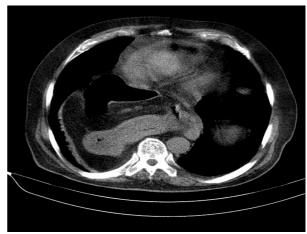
CT scan of Bochdalek hernia
